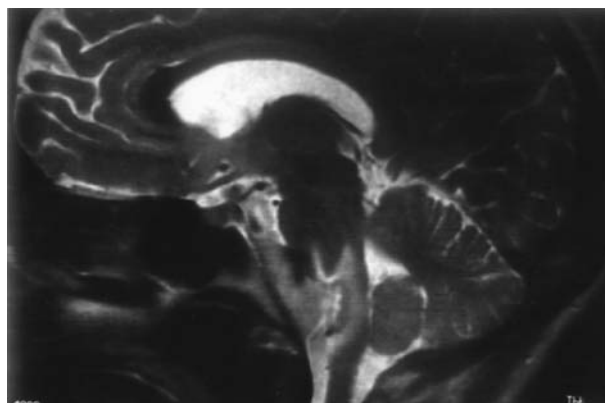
T2-weighted image obtained at 14 months after the treatment, at the time of neurological impairment. Note the broad area of increased signal at the pontomedullary junction
